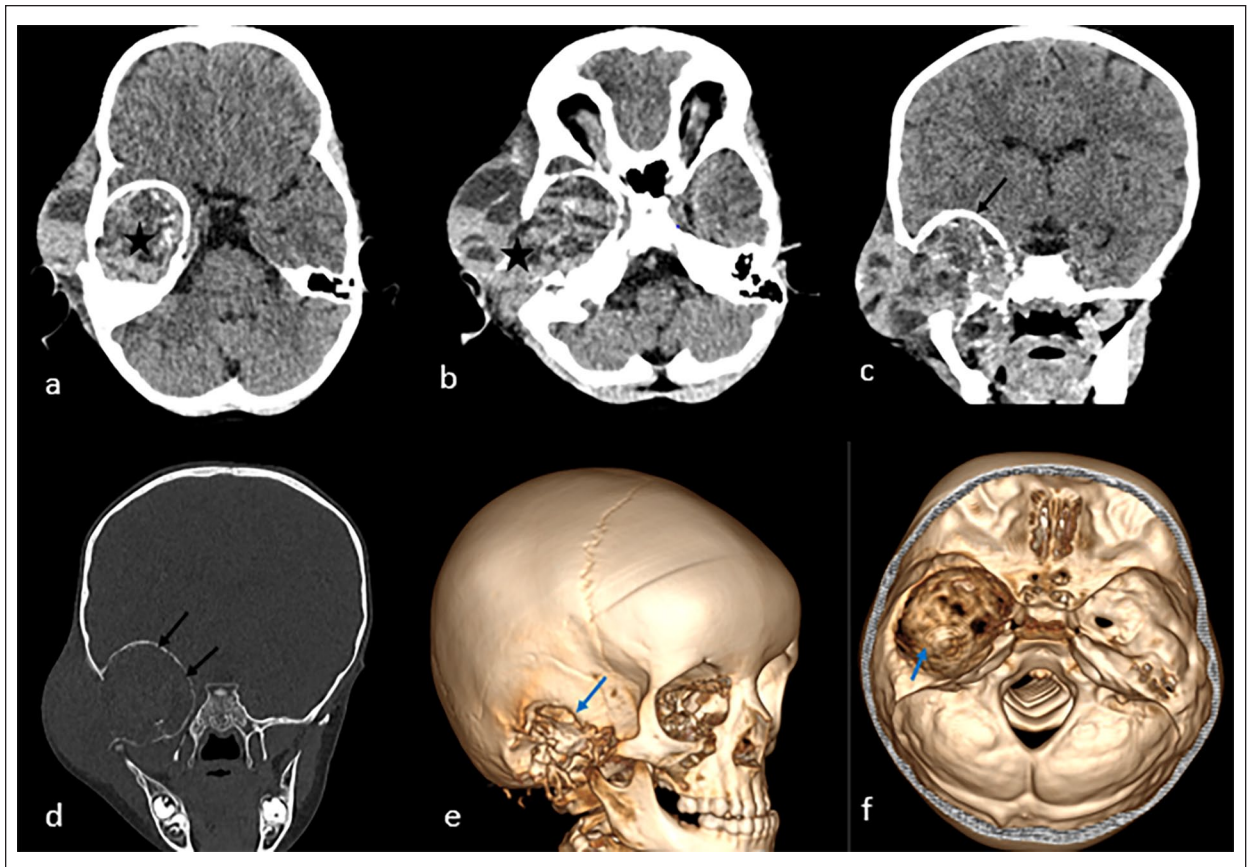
CT images 6 months after surgery: axial sections (a, b) and coronal reconstructions in the parenchymal window (c) and in the bone window (d) demonstrate a significant increase in the size of the tumor (black asterisk) with an accentuation of tumor extension into the temporal lobe and the formation of a peritumoral calcified shell (black arrows). The 3D reconstruction (e, f) reveals bone lysis with deformation of the temporal bone corresponding to the tumor site (blue arrows).
